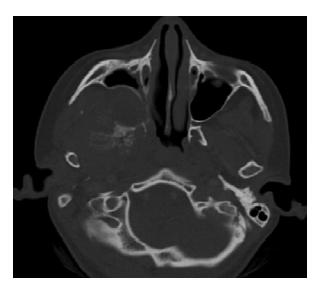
CT with contrast material of the skull base, showing a mass lesion in the right infratemporal fossa, with evident destruction of the retromaxillary space and suspected infiltration of the pterygoid and temporalis muscles.
